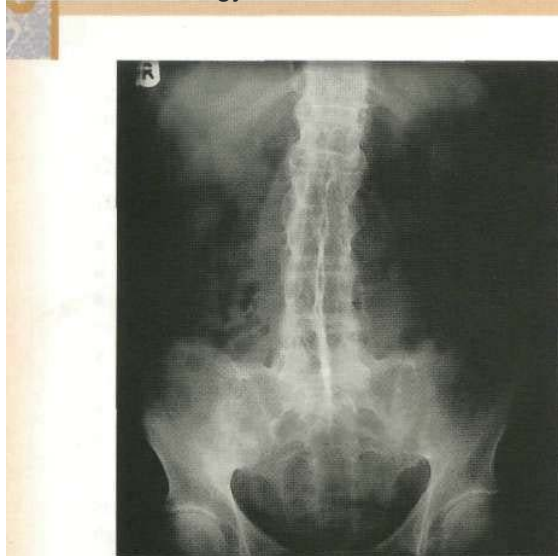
X-ray of bamboo spine in ankylosing spondylitis. In advanced disease there is calcification of the interspinous ligaments and fusion of the facet joints as well as syndesmophytes at all levels. The sacroiliac joints fuse.
